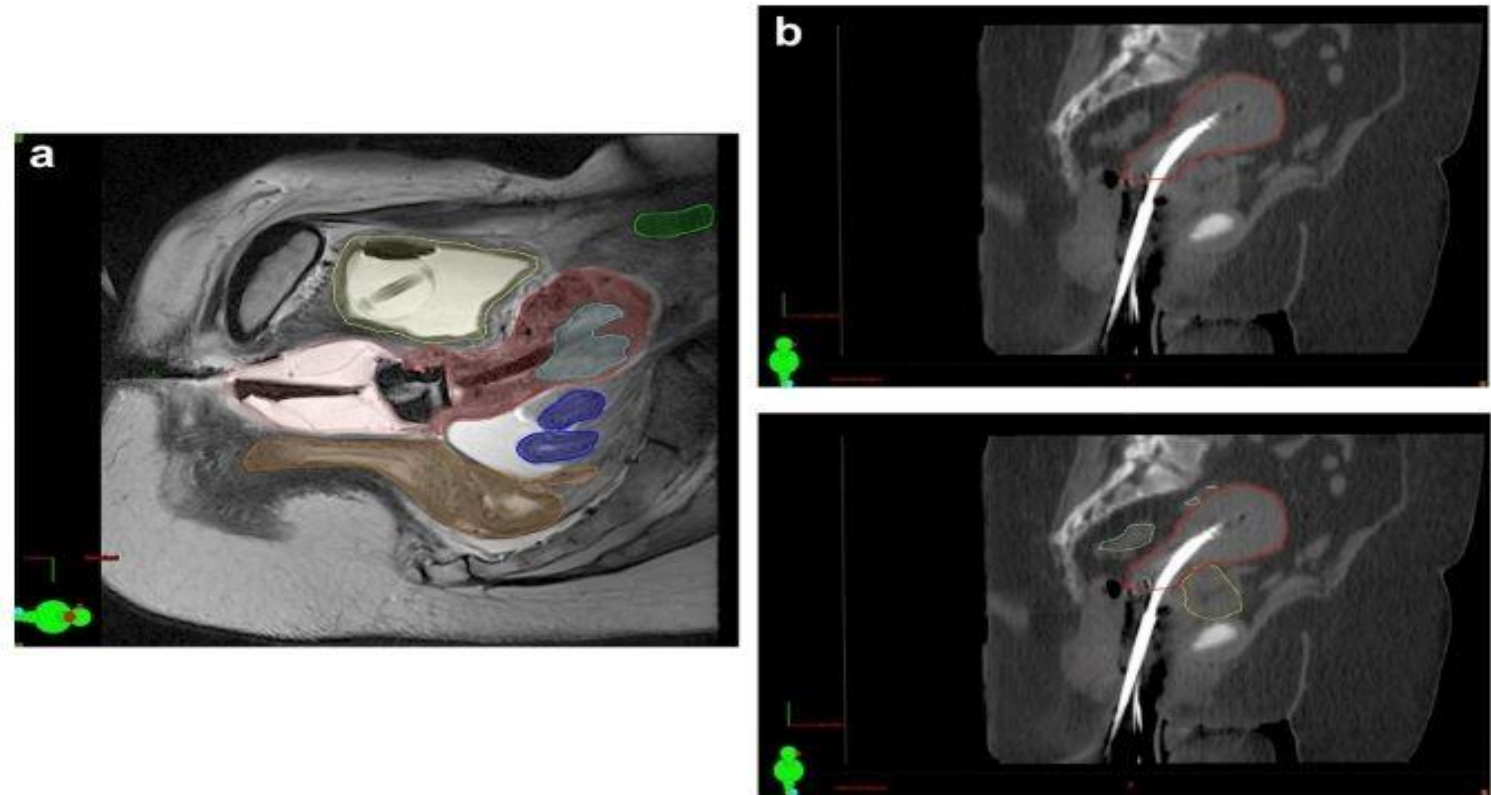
Contouring for medically inoperable endometrial cancer using intraoperative magnetic resonance imaging (MRI) or computer tomography (CT). (a) Sagittal slices of T2-weighted MRI showing gross tumor volume (light blue) and clinical target volume including uterus, cervix, and upper vagina (red) with adjacent sigmoid colon (dark blue), rectum (orange), bowel (green), and bladder (yellow). (b) Sagittal view from a CT image data set displaying the uterus (red) for a tandem and ovoid implant with Heyman capsules displayed without and with the surrounding organs at risk, that is, sigmoid (light green), bladder (yellow), and rectum (brown).
